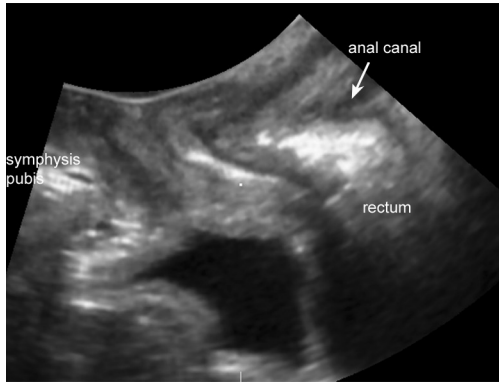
Posterior rectocele on ultrasound
